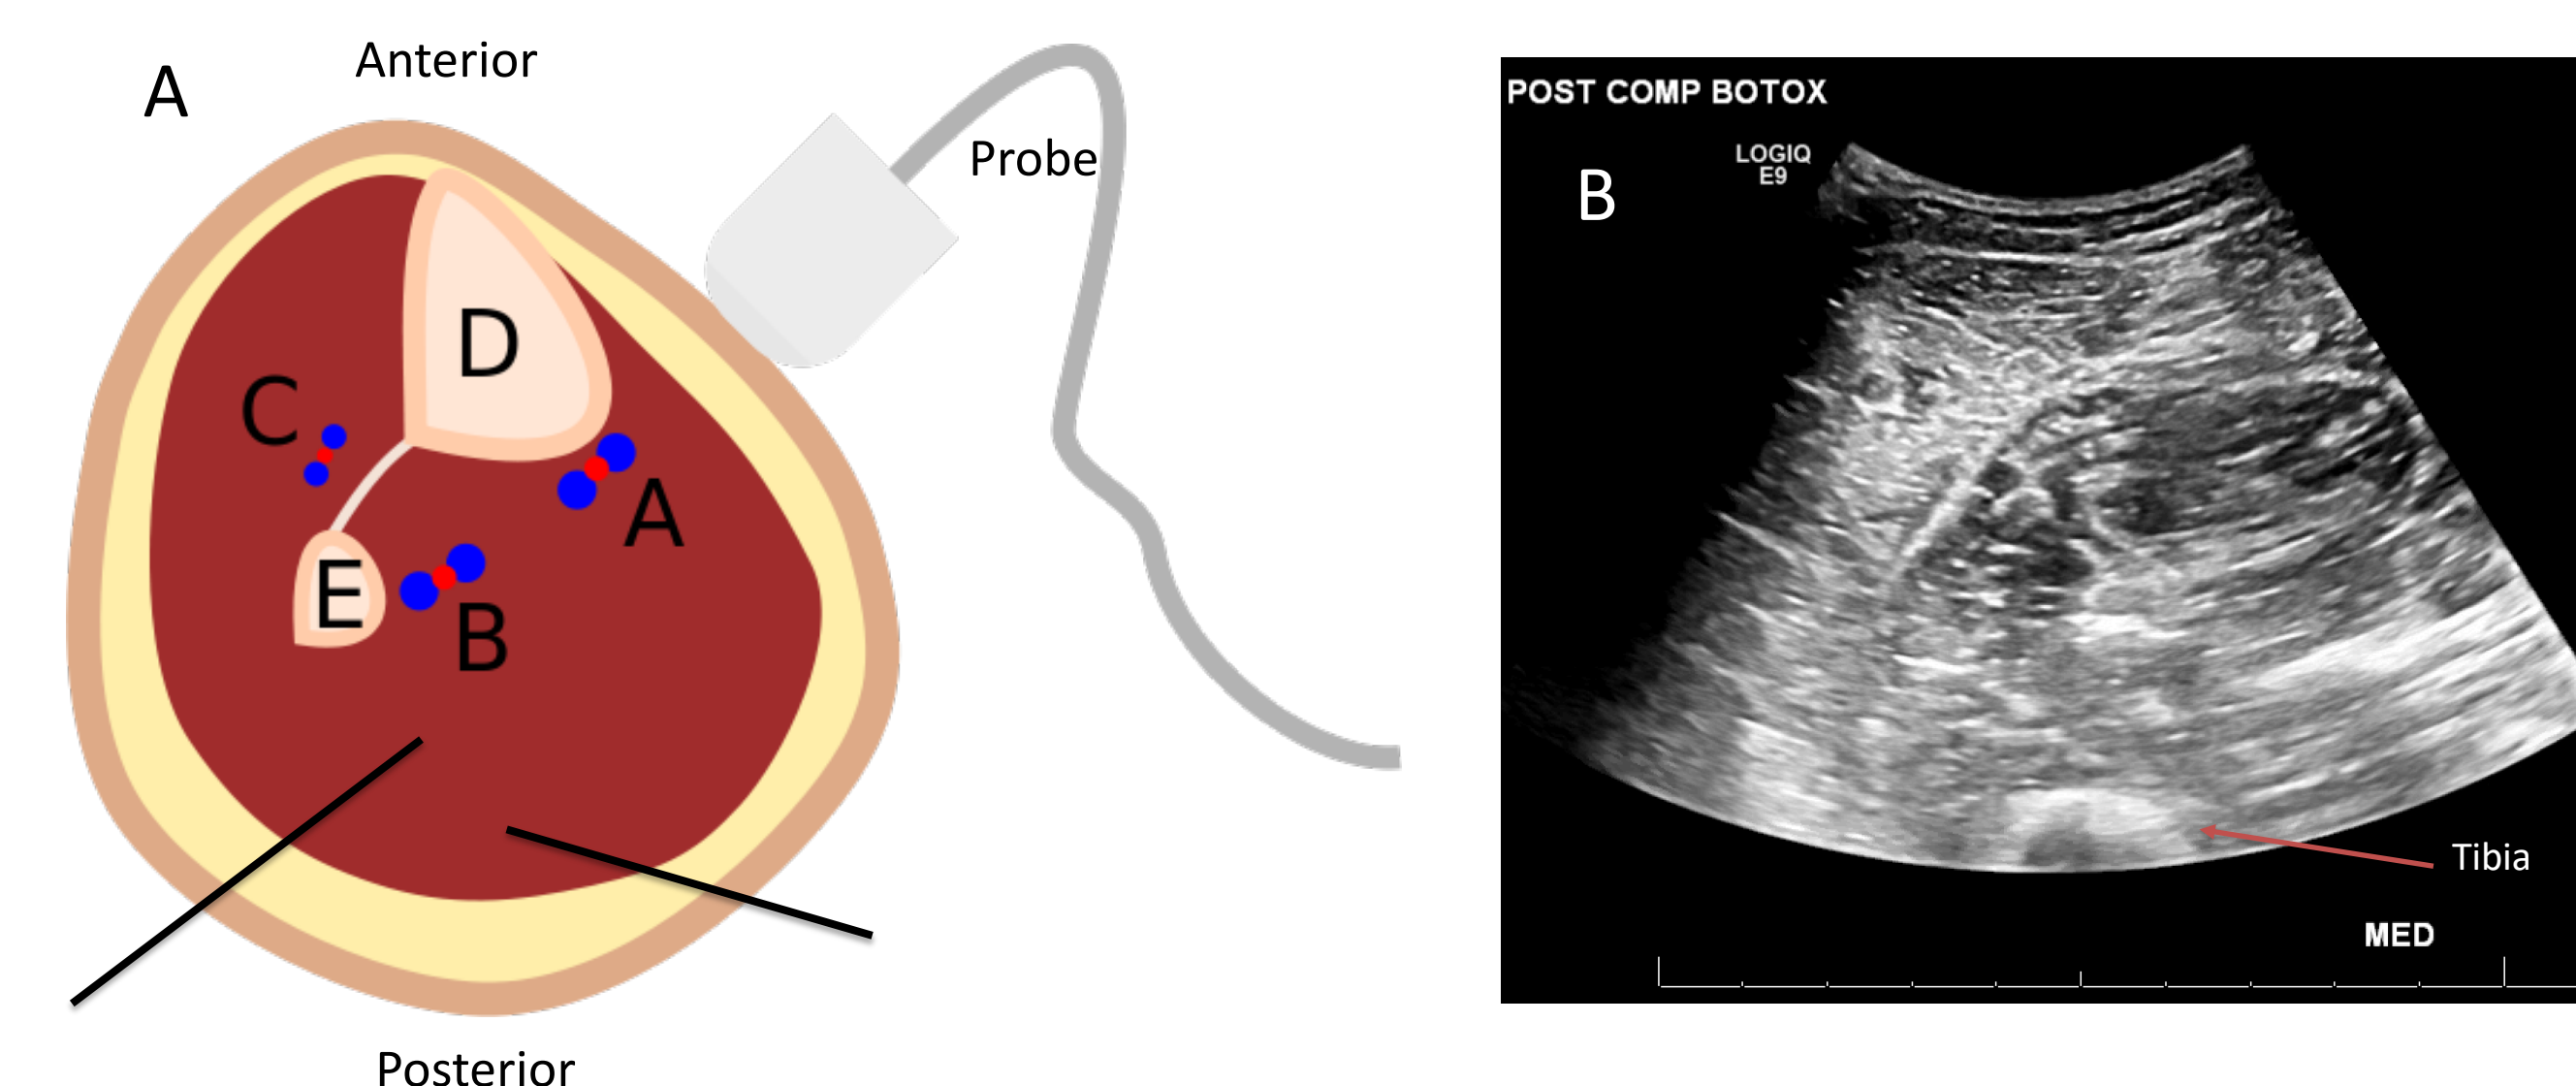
Injection technique under sonographic guidance
